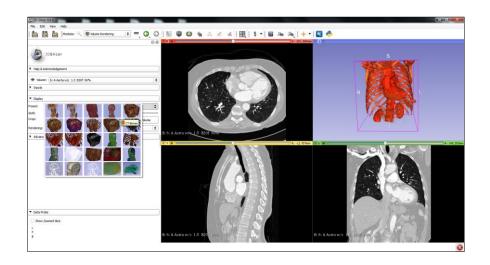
3DSlicer, Volume Rendering, Display Properties, Selecting a Preset, CT-Bones
